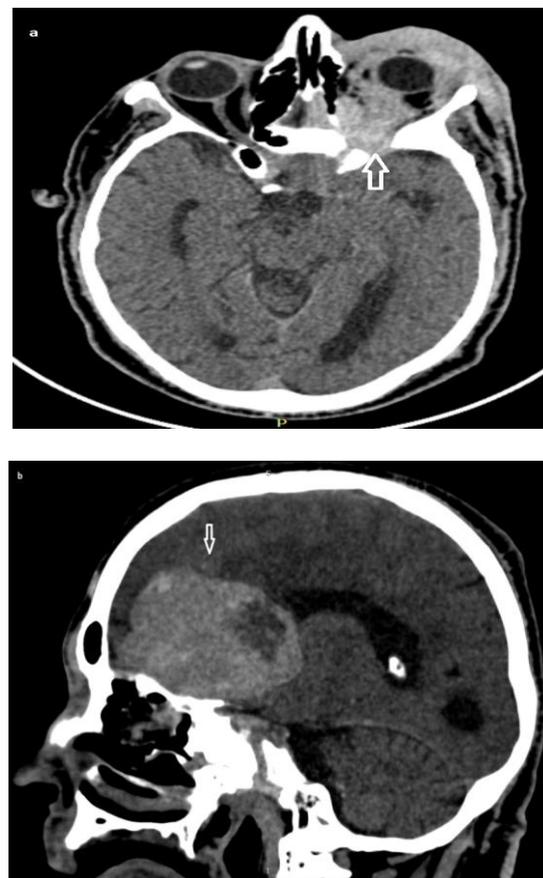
Non-contrast brain computed tomography (CT) scan in axial section (a) and coronal reconstruction (b), showing a spontaneously hyperdense frontal extra axial tumor, heterogeneous with large base of implantation (b, arrow), associated with a left orbito palpebral tumor (a, arrow).
